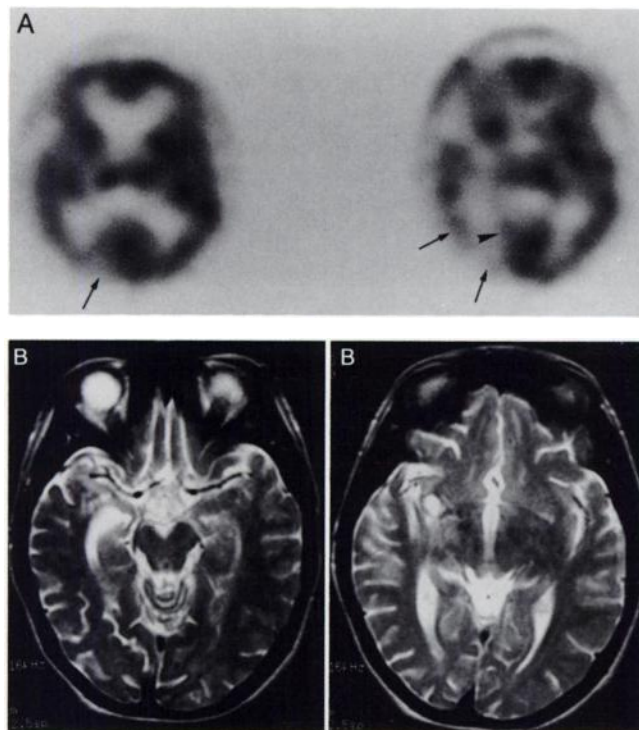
SPECT and MRI of Patient 2, who suffered a left homonymous hemianopia from trauma. (A) SPECT reveals hypoperfusion of the right lateral occipital lobe (arrows) and primary visual cortex (arrowhead) which correlated the visual field defect. (B) MRI shows only bilateral lacunes of the deep white matter and the basal ganglia.
